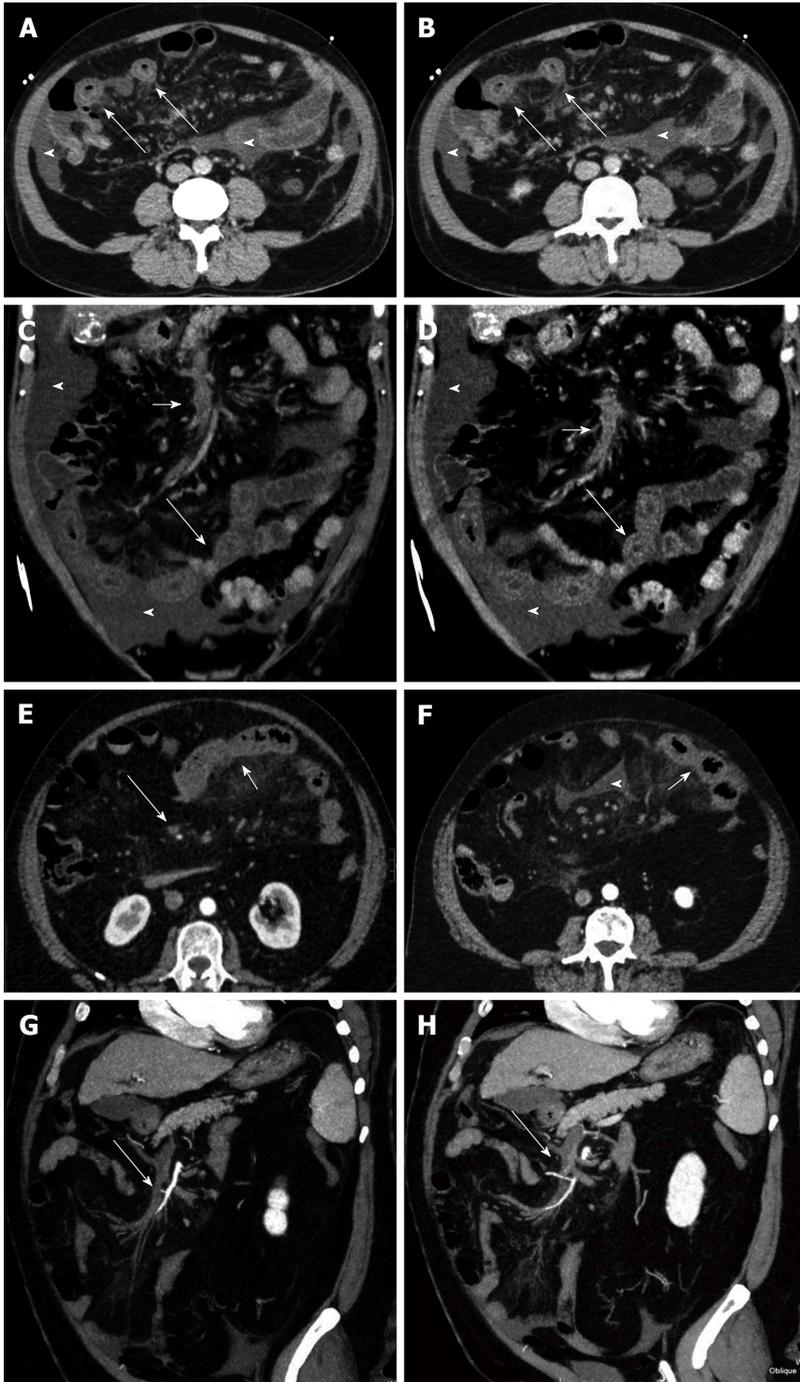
Venous mesenteric ischemia. A and B: Transverse computed tomography (CT) scans; C and D: Coronal MPR reconstructions. Bowel ischemia caused by the occlusion of the superior mesenteric vein (short arrows). The target sign with concentric bowel wall thickening is well evident (long arrows). Ascites is associated (arrowheads); E and F: Transverse CT scans; G and H: Coronal curved multiplanar reconstructions. Bowel ischemia caused by the occlusion of the superior mesenteric vein (long arrows). The target sign with concentric bowel wall thickening is well evident (short arrows). Ascites is associated (arrowheads).
